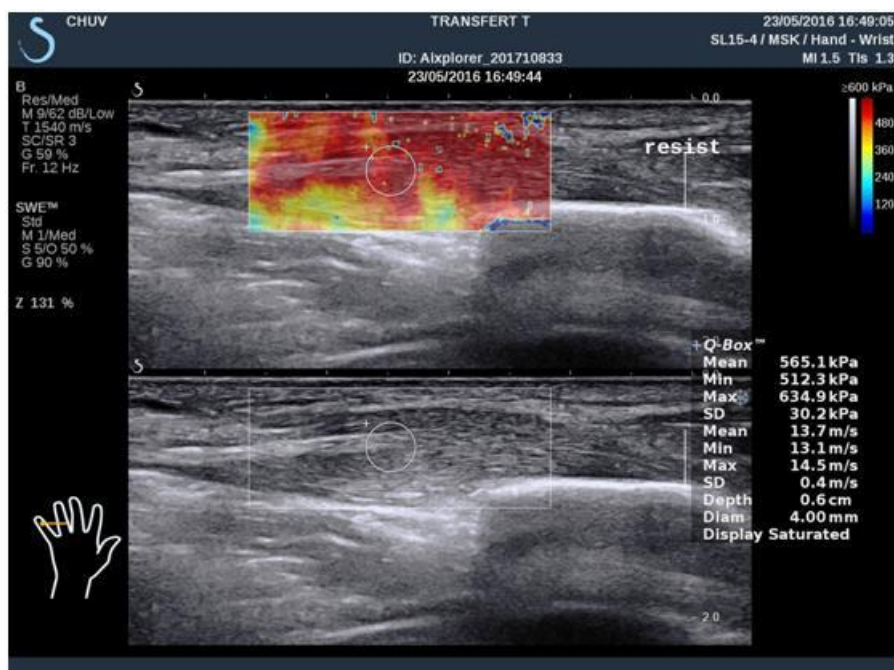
B-mode ultrasound (low) and elastographic (high) recording during the 3rd stage of the transfer (AER).
